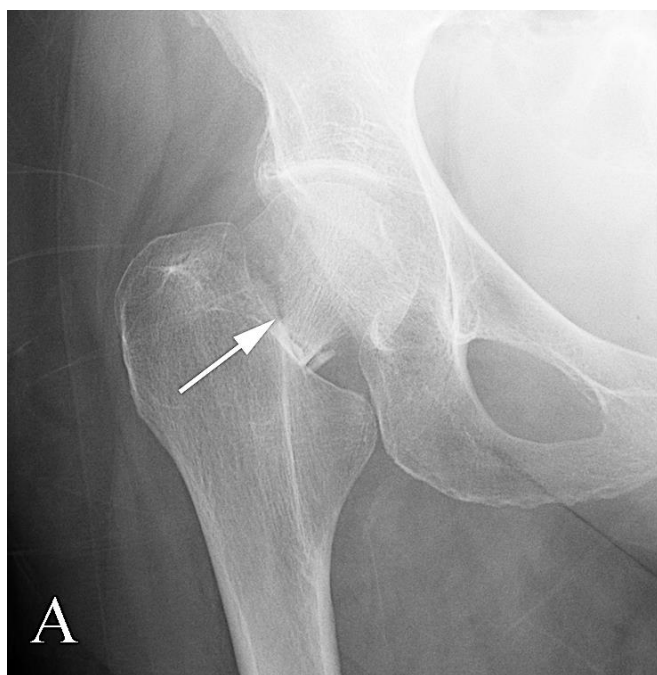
Proximal femur fracture in a 75 year old with pain following trauma. A. AP plain film of the hip shows a fracture through the base of the femoral neck (arrow) with associated shortening of the femur. B. Axial view of the hip shows anterior angulation of the fracture apex (arrow).
